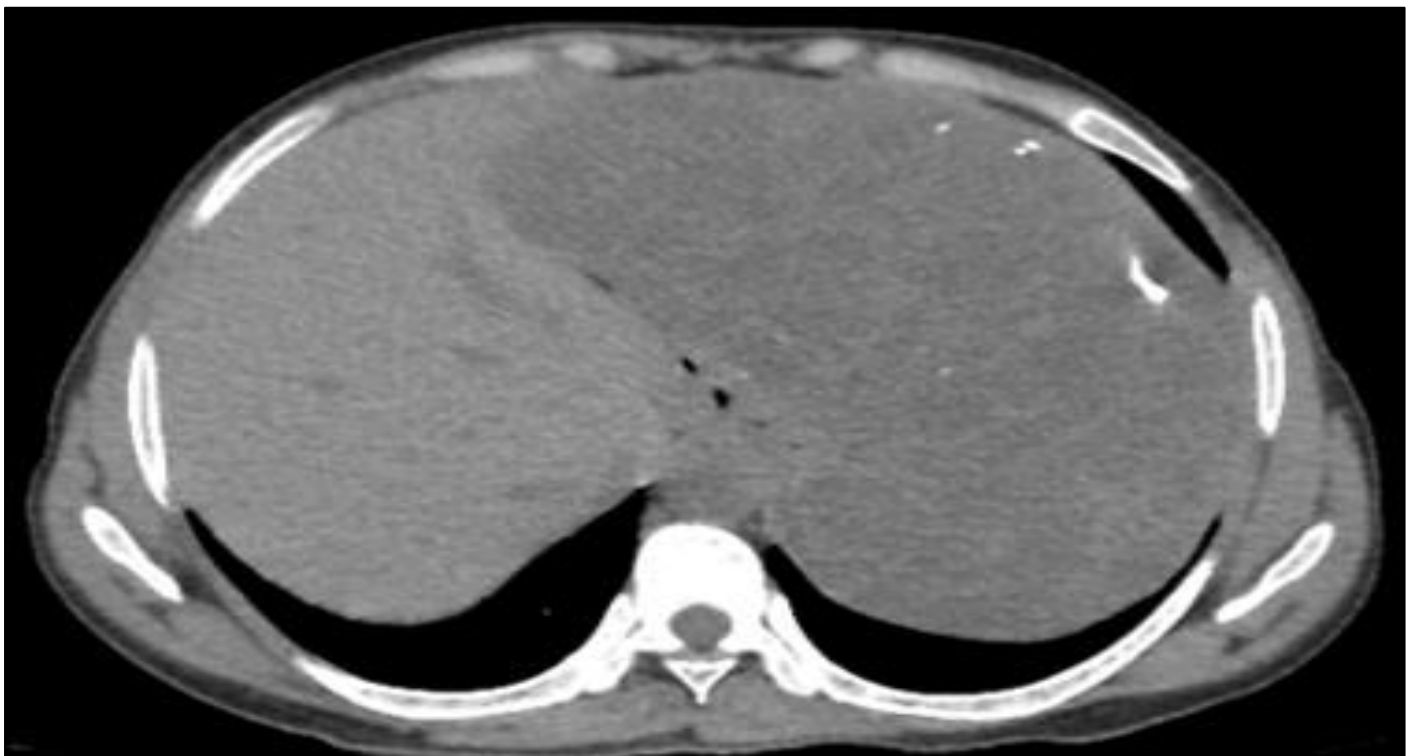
Plain CT Abdomen Showing Enlarged Spleen with Multiple Hypodense Lesions & Calcifications in Splenic Parenchyma.
